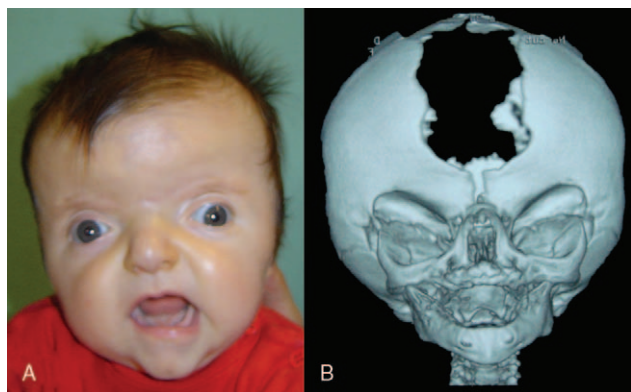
(A) Typical facies in Apert syndrome. The intercanthal distance is wide with down-slanting palpebral fissures and maxillary hypoplasia with a high palatal arch. (B) The computed tomography scan confirms the bony deformation namely hypertelorbitism with maxillary hypoplasia. Notice the wide anterior fontanelle that is typical of this deformity.
